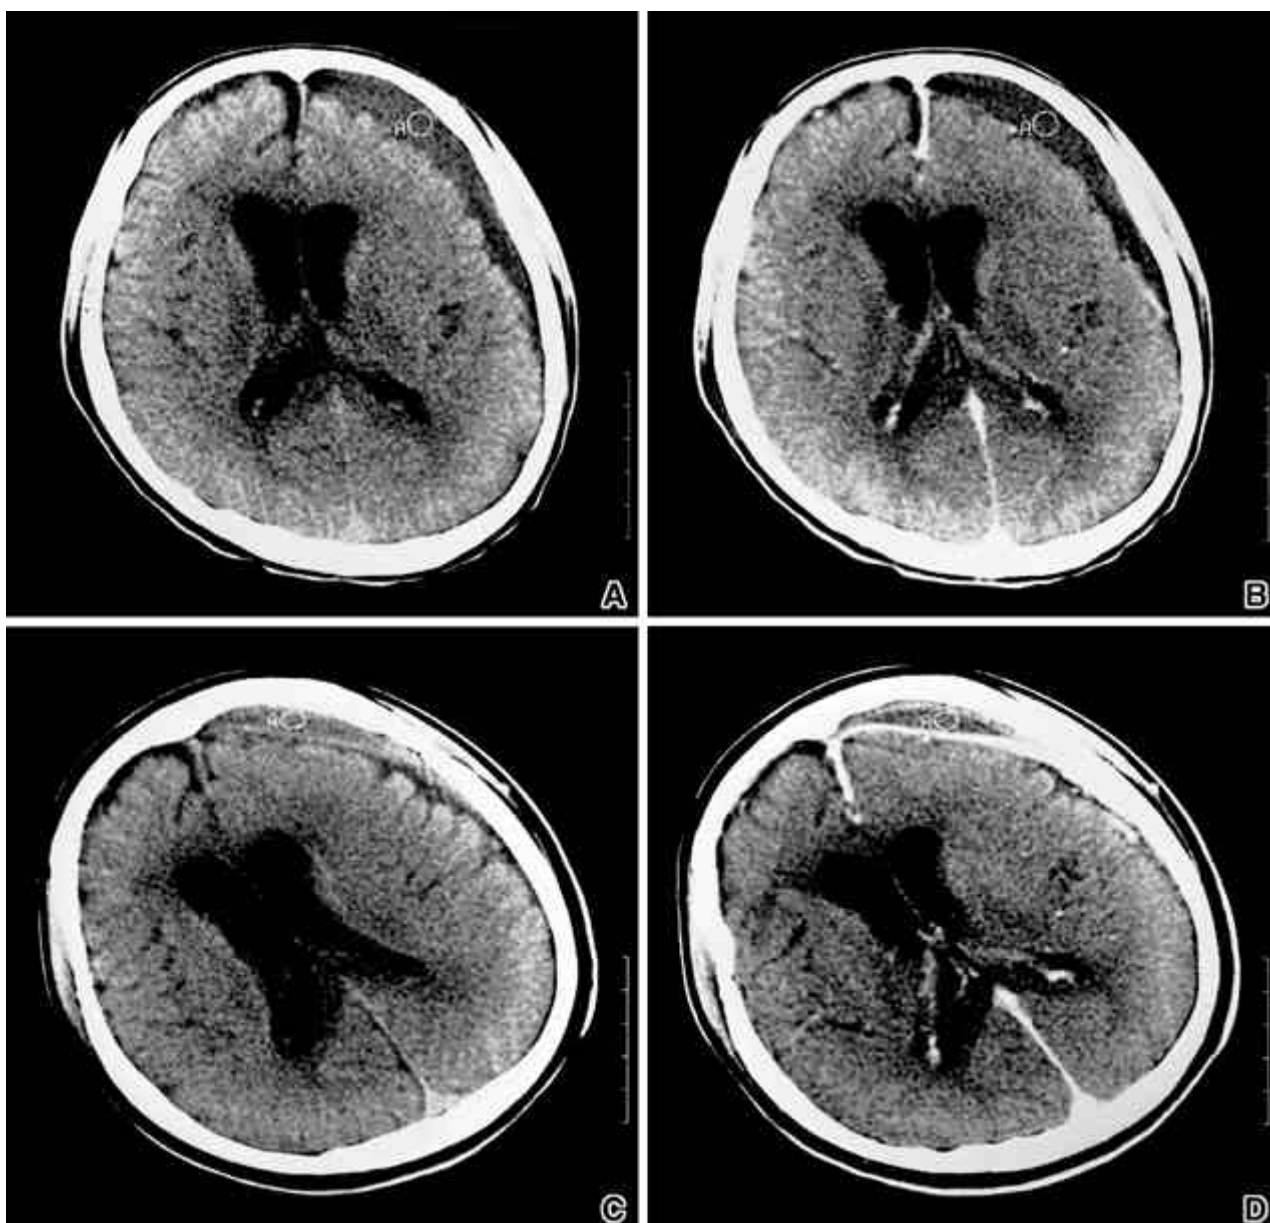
Pre (A, C)- and post (B, D)-enhanced CT scans of CSDH from SDG in a 33 year old male patient on Day 117 (A, B) and Day 397 (C, D). The density of the lesion is 25.4 (A, B) and 39.0 (C, D) Hounsfield Units in pre-enhanced CT scans.
